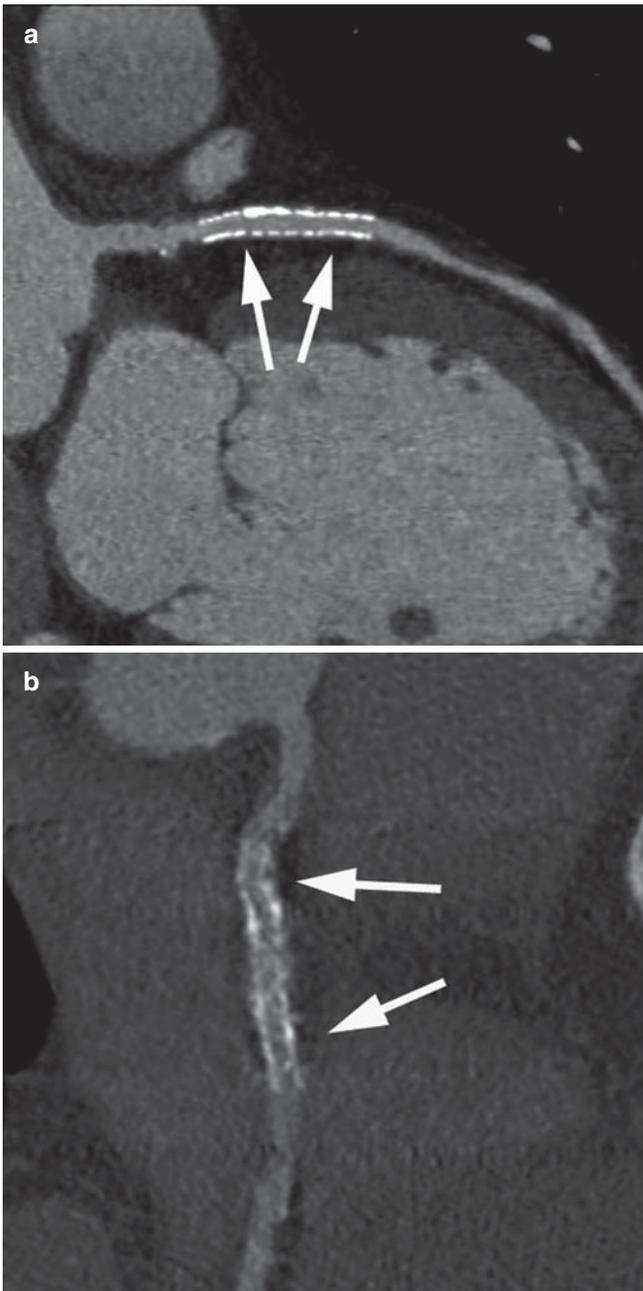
Imaging of coronary artery stents by CT angiography. (a) Visualization of a stent implanted in the proximal left anterior descending coronary artery. No artefacts are present and the in-stent lumen can be assessed very clearly (arrows). (b) In this case, motion artefacts are present, which make it impossible to assess the lumen of two stents implanted in the proximal right coronary artery
